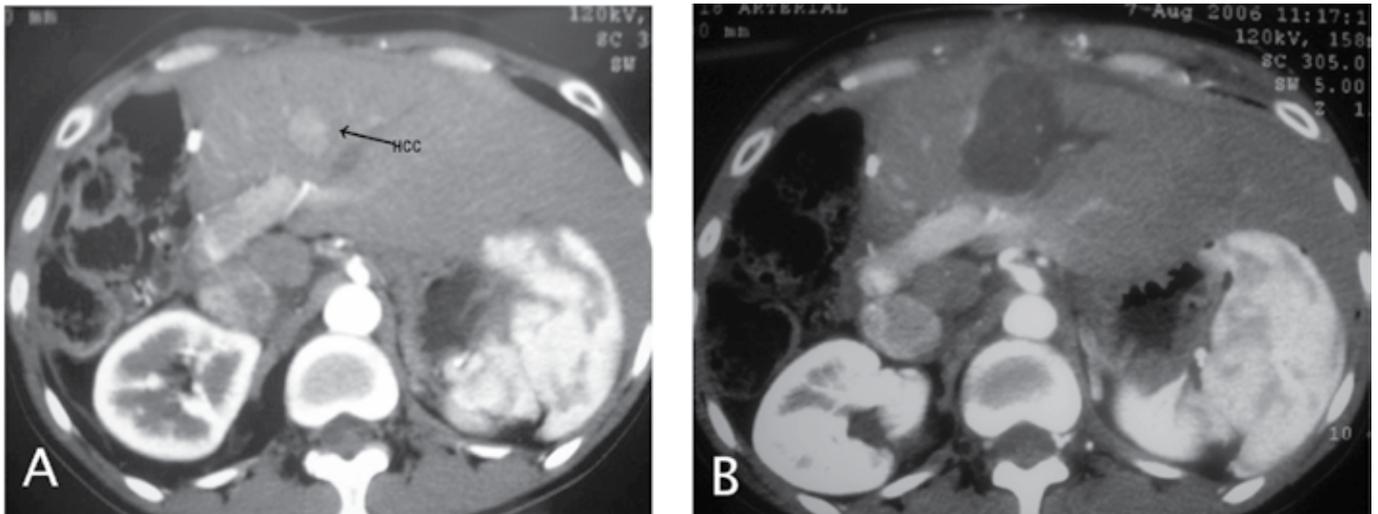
Computed tomography of hepatic lesion before (A) and after (B) after radiofrequency ablation. Hepatocellular carcinoma after right hepatectomy in a noncirrhotic liver
